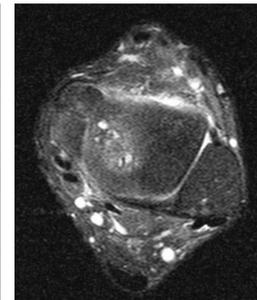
Case 1, 9mo Post-Op MRI: Improved signal intensity within PT tendon
